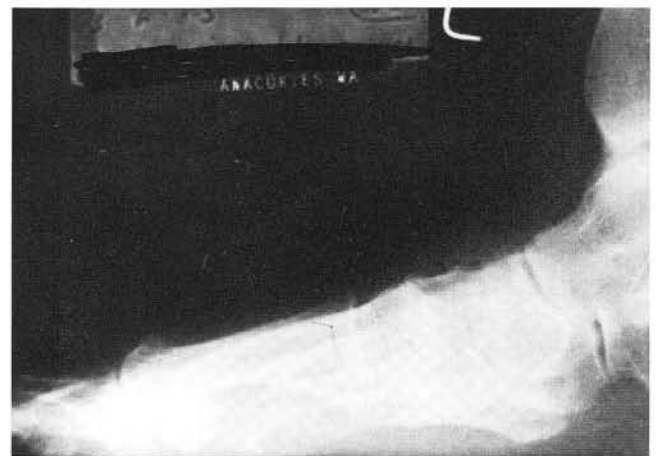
Preoperative radiograph, lateral view.
